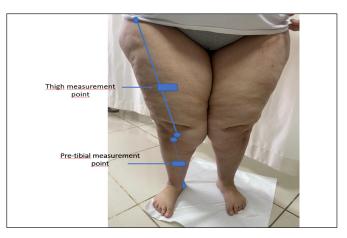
Thigh and pretibial measurement points where ultrasonographic soft tissue thicknesses are evaluated (Modified from Amato et al. 2021)
